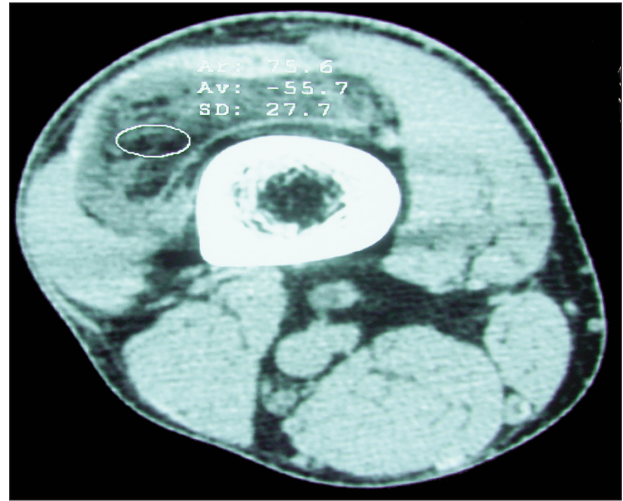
CT scan, axial view showing fat density in the supra-patellar pouch
